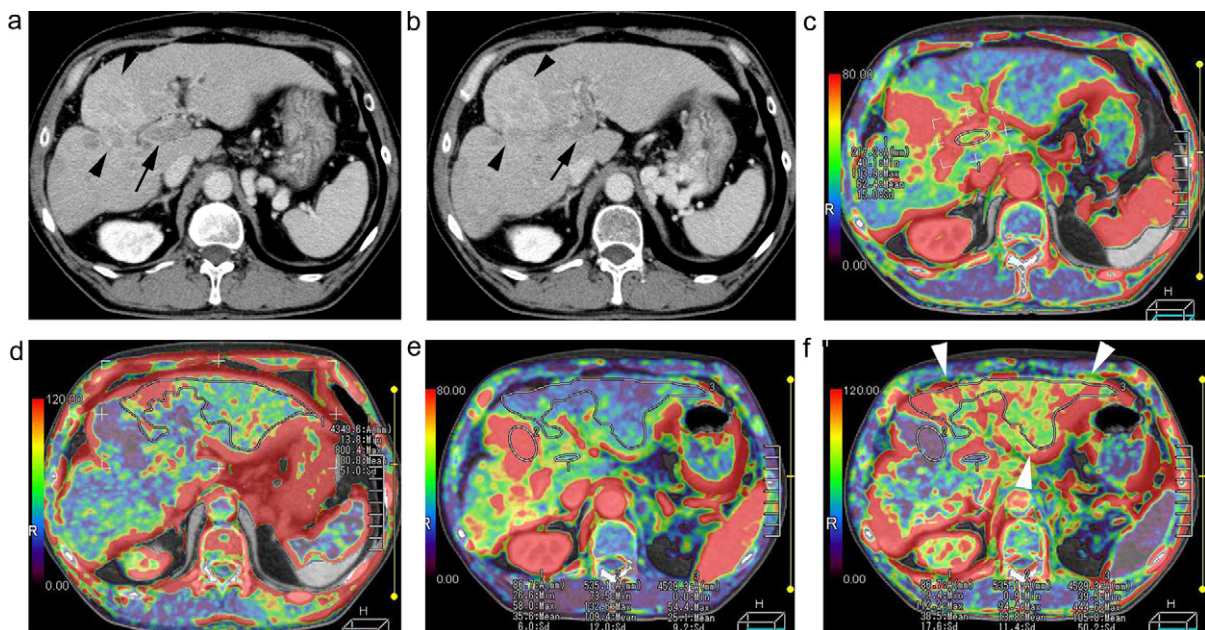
A 60-year-old man with clinically diagnosed hepatocellular carcinoma accompanied by intra-portal tumor invasion. Contrast-enhanced CT images at time of the first CT perfusion are shown as (a) and (b). He received transcatheter chemoembolization for intra-hepatic tumors ((a) and (b), arrowheads) and radiation therapy for intra-portal tumor invasion ((a) and (b), arrows). CT hepatic arterial perfusion map (c) shows an increase in arterial perfusion in the intra-portal tumor and the portal perfusion map (d) shows a decrease in portal perfusion in the non-cancerous parenchyma. Following CT perfusion 1 week after the end of radiation therapy, the hepatic arterial perfusion map (e) shows a decrease in arterial perfusion in the intra-portal tumor and the portal perfusion map (f) shows recovery of portal perfusion, especially in left lobe of the liver (arrowheads).
